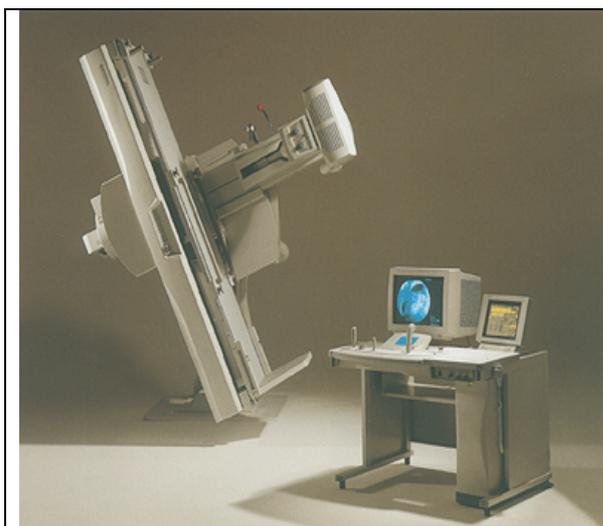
Modern X-ray machine.
